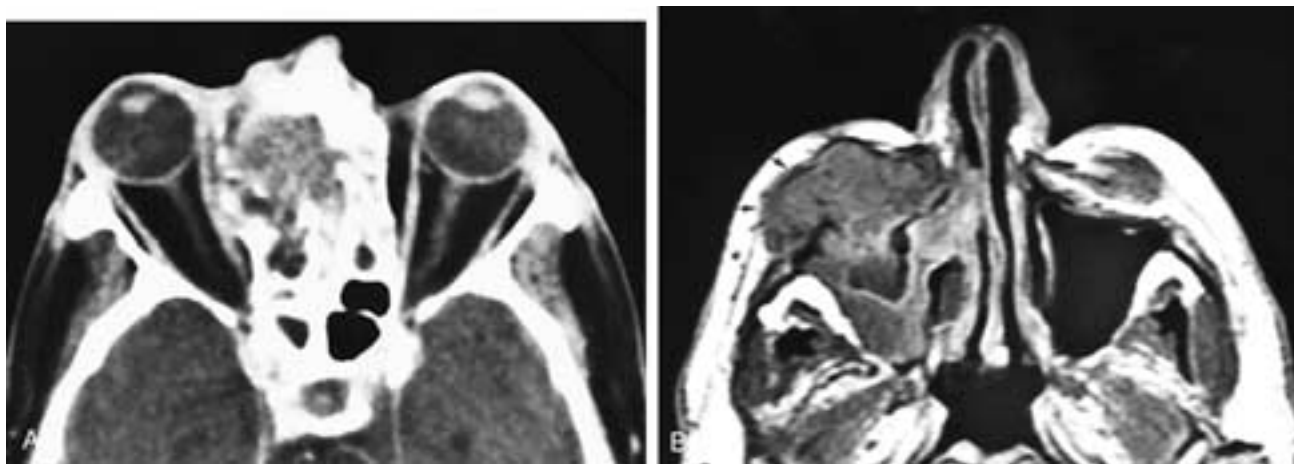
Axial CT scan (A) shows an expansile right anterior ethmoid mass that erodes the lamina papyracea and bulges into the right orbit. This patient had a malignant schwannoma. Axial T1-weighted MR image (B) on another patient shows a destructive lesion originating in the roof of the right maxillary sinus (arrows). The mass has a low T1-weighted signal intensity and an intermediate T2-weighted signal intensity. This patient had a malignant schwannoma of V₂.
